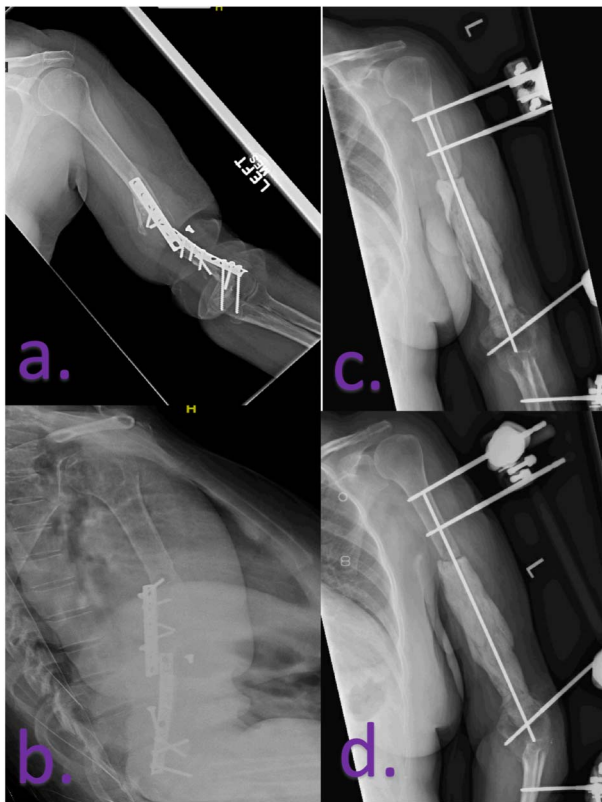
Initial and first stage IMT radiographs. Initial AP (A) and transthoracic lateral (B) of the left humerus demonstrating atrophic nonunion with hardware failure. Six weeks postoperative first stage IMT: AP (C) and lateral (D) plain radiographs of the left humerus with external fixator and antibiotic cement spacer over a guidewire. AP, anteroposterior; IMT, induced membrane technique.
